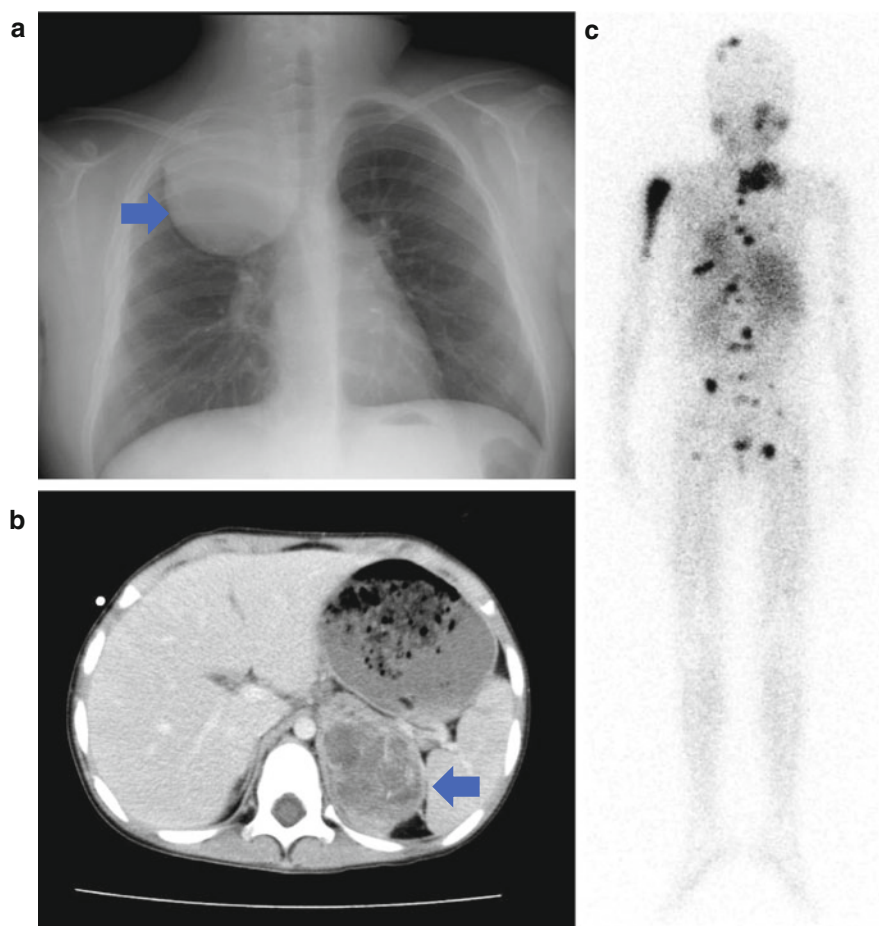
Clinical presentations of neuroblastoma. a Localized thoracic neuroblastoma. *Arrow* indicates tumor mass. b Enhanced abdominal computed tomography. *Arrow* indicates large tumor in adrenal medulla. c Metastatic neuroblastoma revealed by Metaiodobenzylguanidine (MIBG) scintigraphy
